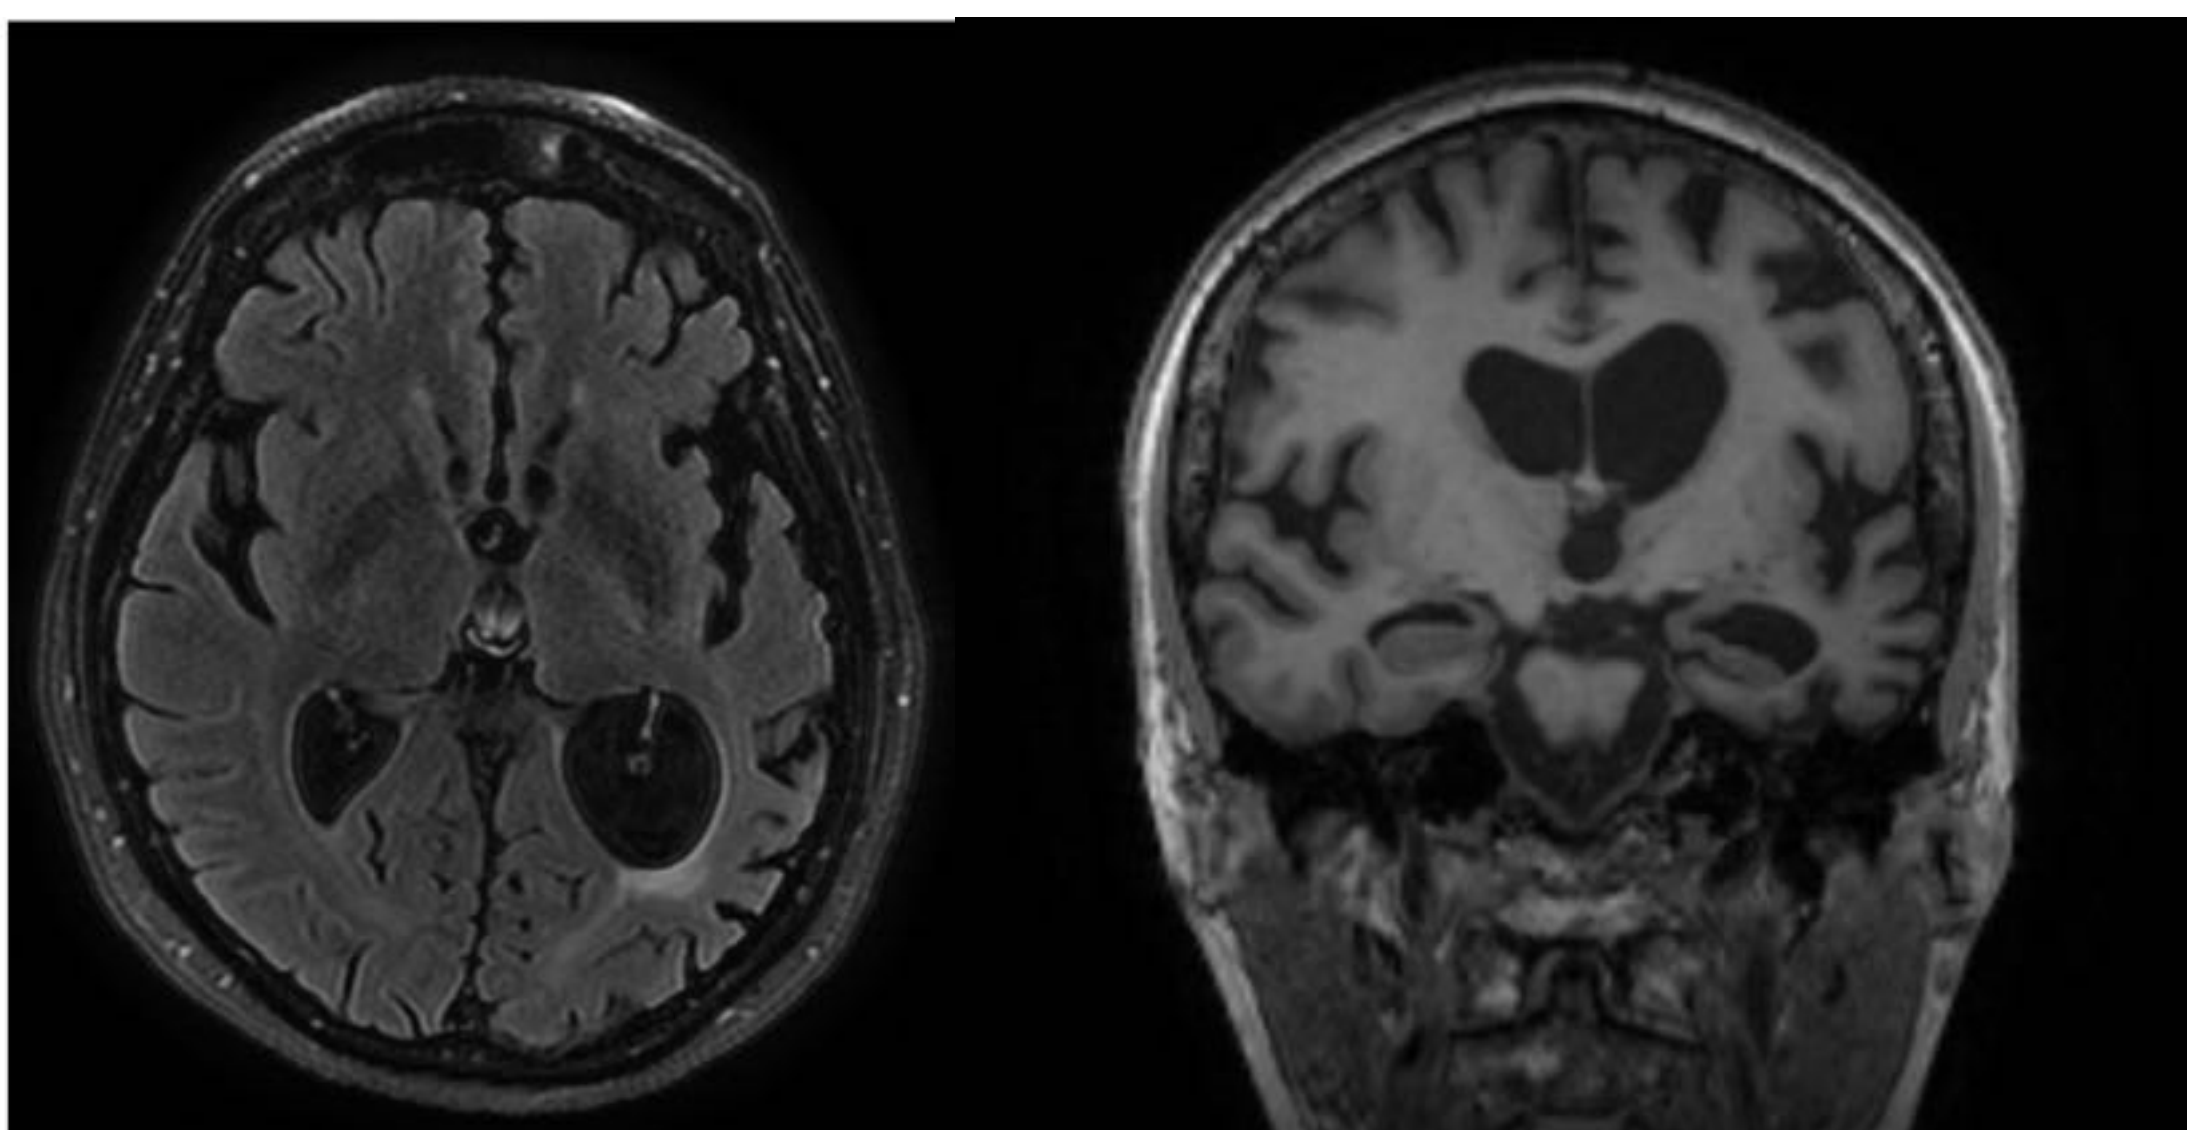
MRI showing cortical fronto-temporal atrophy (left>right) in Axial FLAIR and Coronal T1 sequences
